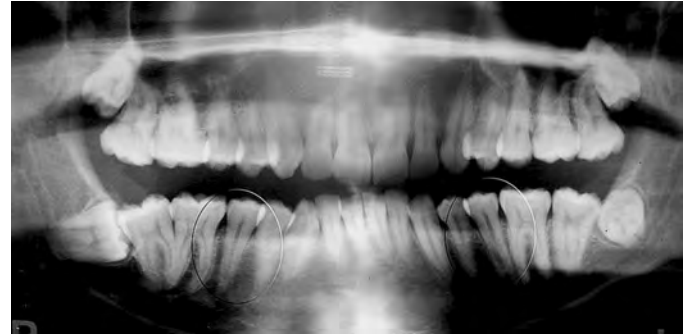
Panoramic radiograph showing mandibular left second premolar with two roots and mandibular right second premolar with only one root. Case is a 21 year old female.
